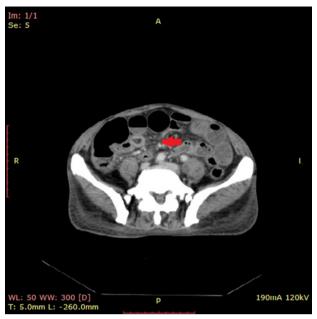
Axial section of CT abdomen showing dilated jejunal and ileal loops with transition at distal ileum
